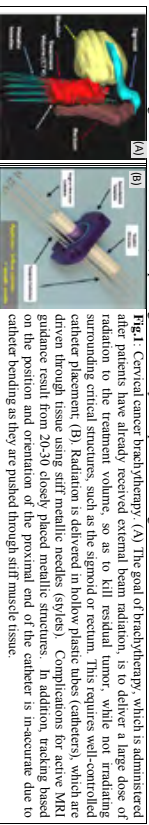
(A) Coronal cancer brachytherapy. The goal of real-time tracking is to deliver a large dose of radiation to the treatment volume, so as to kill residual tumor, while not irradiating surrounding critical structures, such as the sigmoid or rectum. This requires well-controlled catheter placement. (B) Radiation is delivered in hollow plastic tubes (catheters), which are driven through tissue using stiff metallic needles (stylets). Complications for active MRI guidance result from 20-30 closely placed metallic structures. In addition, tracking based on the position and orientation of the proximal end of the catheter is inaccurate due to catheter bending as they are pushed through stiff muscle tissue.
